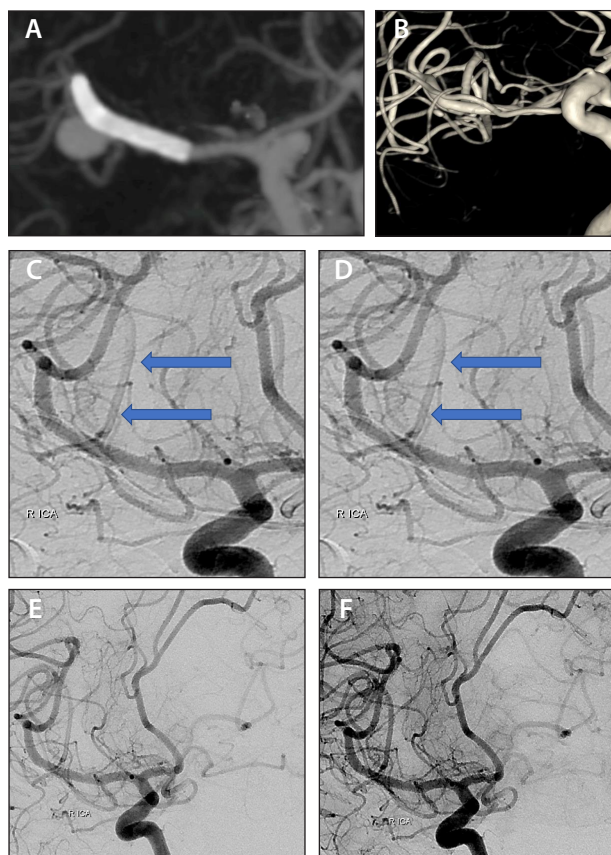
Six-month control CTA showing filling of the aneurysm with the patency of both MCA trunks (A). One-year control DSA (B-F) showing total occlusion of the MCA aneurysm, a patent superior trunk, and retrograde filling in the inferior trunk through pial anastomosis with only minimal delay (arrows; C, D).
